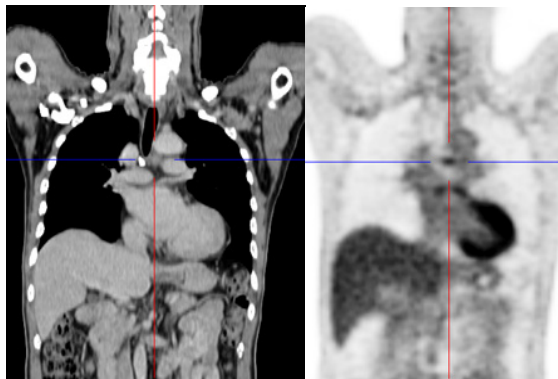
Example of discordant positron emission tomography (PET) and computed tomography (CT) results. CT (left) images of a mediastinal lymph node showing a subcentimeter lymph node. The corresponding PET image (right) exhibited an FDG-avid lymph node denoting the altered glucose metabolism suspicious for pathological lymph node. [Images courtesy of *Pusat Pengimejan Diagnostik Nuklear*]
